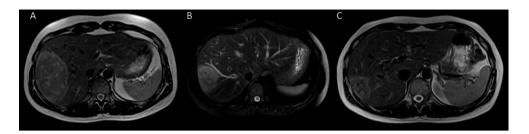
MRI of growing HCA.
